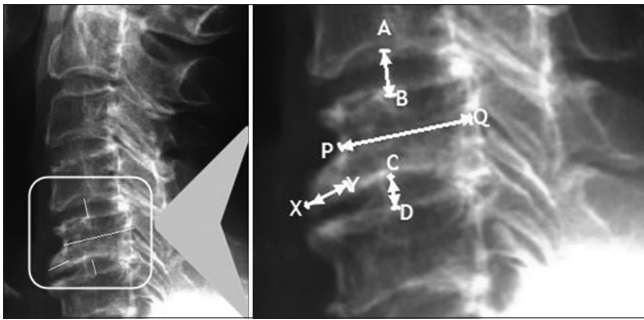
Lateral X-ray of cervical spine shows height loss and size of anterior osteophytes, A-B: normal middle disc height at an adjacent level, C-D: middle disc height at the degenerated level, P-Q: anterior posterior diameter of the vertebral body, X-Y: length of anterior osteophytes, Height loss (CD/AB) and size of anterior osteophytes (XY/PQ)
